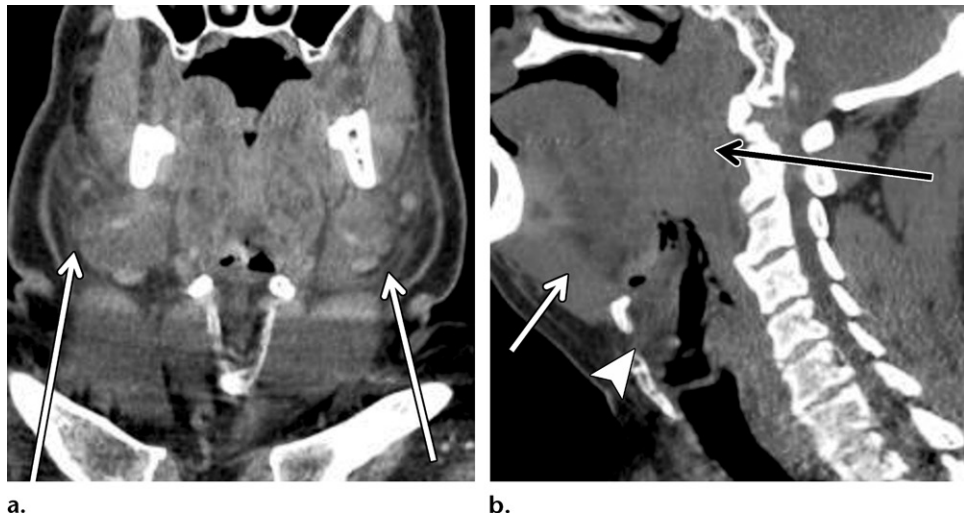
ACE inhibitor–mediated angioedema in a 59-year-old man with hypertension who presented with 4 days of hoarseness, oral edema, difficulty swallowing, and drooling. Coronal (a) and sagittal (b) CT images show diffuse transspatial edema involving the bilateral submandibular spaces (white arrows in a), tongue, floor of the mouth (white arrow in b), pre-epiglottic space (arrowhead in b), and pharynx (black arrow in b), causing marked pharyngeal airway narrowing.
